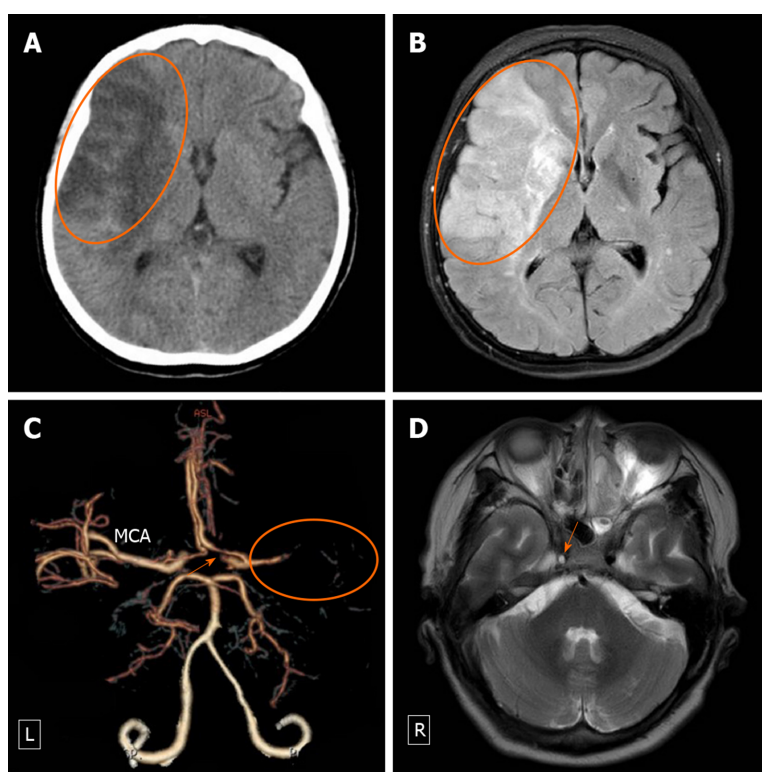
Imaging of case 5. A and B: Computed tomography (A) and (B) magnetic resonance imaging scans showed cerebral infarction in the territory of the right middle cerebral artery (ellipses); C: Computed tomography angiography revealed tapering occlusion of the right middle cerebral artery (ellipse), and the internal carotid artery in the cavernous sinus segment became thin and irregular (arrow); D: Magnetic resonance imaging showed right internal carotid artery dissection depicted as a partial flow-void lumen surrounded by high-intensity signals of an intramural hematoma (arrow). MCA: Middle cerebral artery.
